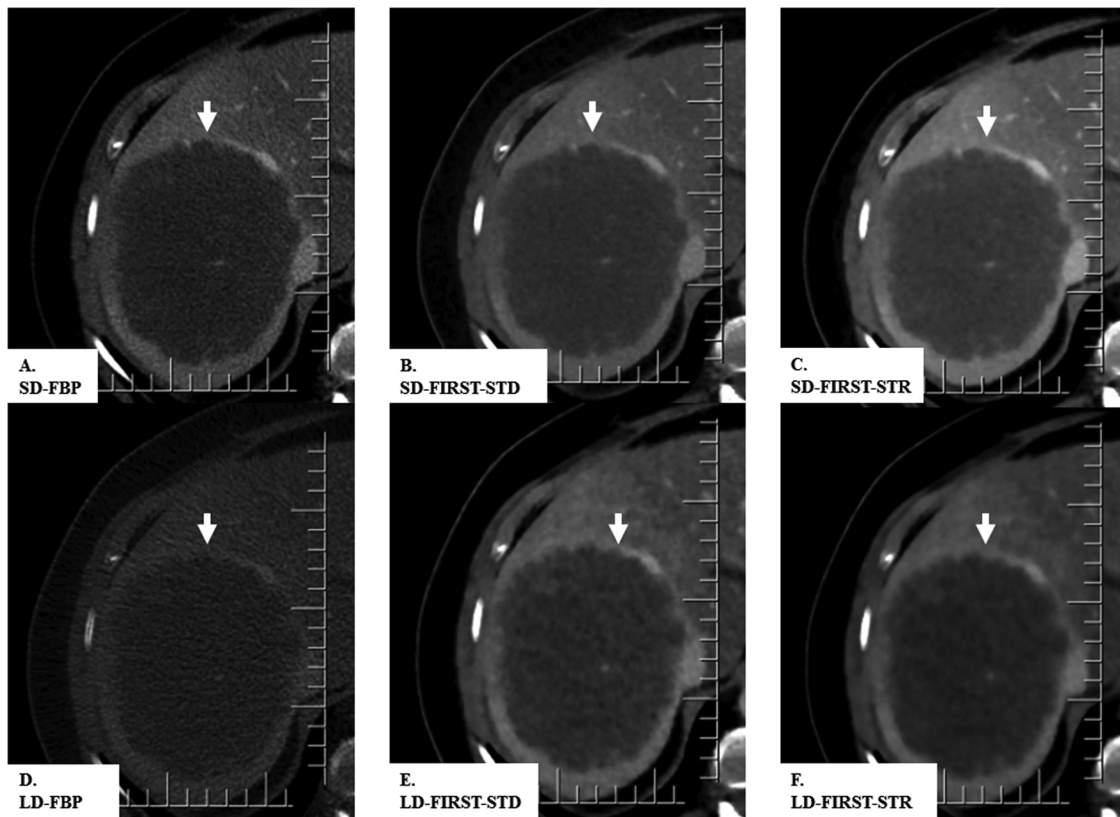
A 68-year-old woman (BMI 32 kg/m²) underwent contrast-enhanced abdomen CT at SDCT (CTDIvol 22 mGy) and LDCT (2.8 mGy). All SDCT and LDCT images demonstrate a necrotic hepatic lesion (white arrow) in the right hepatic lobe. LD-FIRST images had lower noise and better diagnostic performance than the LD-FBP image.
